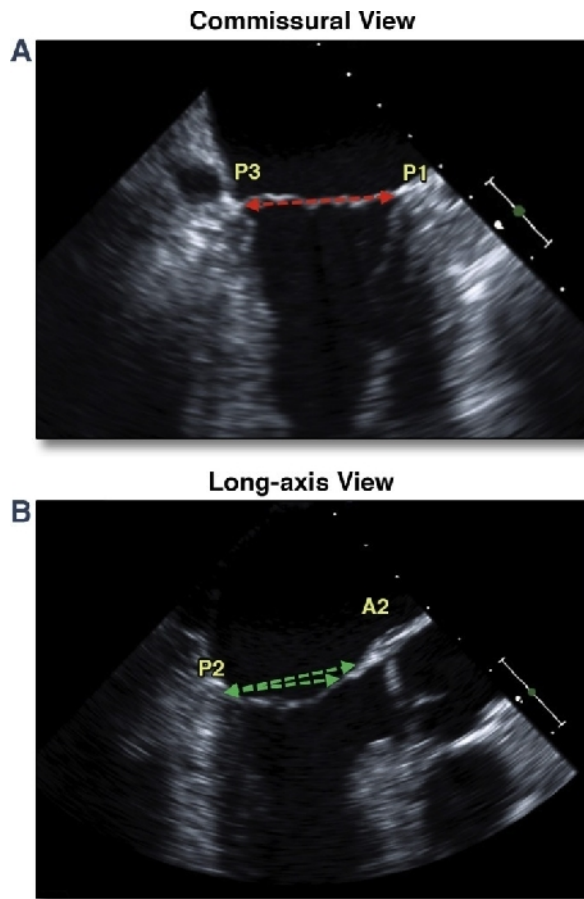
2D Cardiac Views and MA Measurements in TEE. Commissural view transecting the annulus at P1-P3, typically yielding the major MA diameter (A). Perpendicular long-axis view transecting at A2-P2 (B), yielding the minor MA diameter. In contrast to P1-P3, there is no distinct landmark at A2 defining the anterior annulus. TEE = transesophageal echocardiography (quoted from Blanke et al., 2015).
